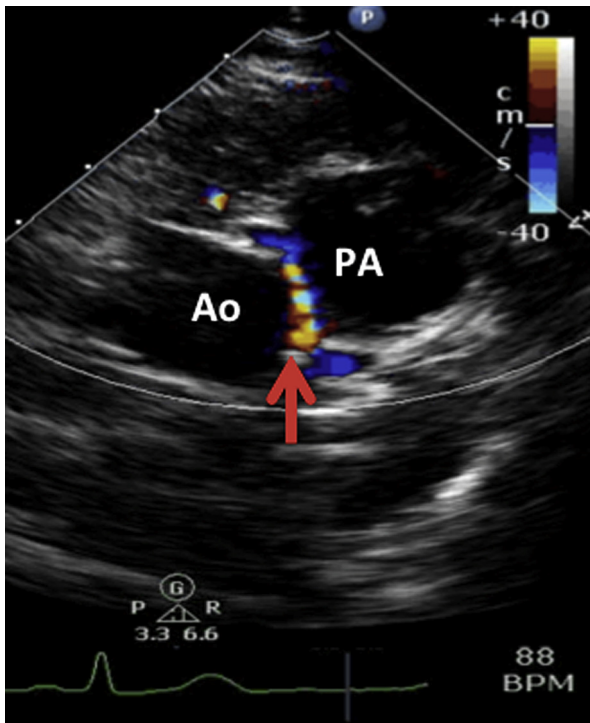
Parasternal short-axis view with color flow Doppler showing a vessel (*red arrow*) coursing between the aorta (Ao) and pulmonary artery (PA), suggesting anomalous RCA from the LMCA.
